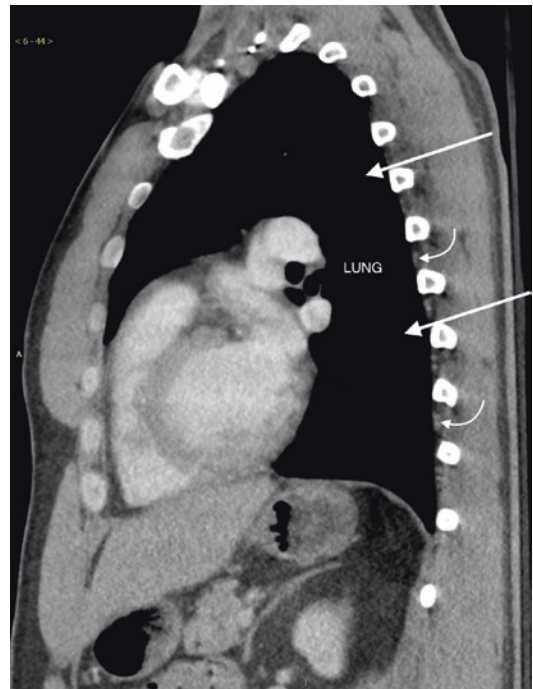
Critical structures to consider when performing a rib biopsy. Sagittal reformation in soft tissue algorithm from a contrast-enhanced chest CT study shows the paired intercostal artery and vein (curved arrows) traveling underneath each respective rib. The ribs only protect a small area of lung (arrows)
